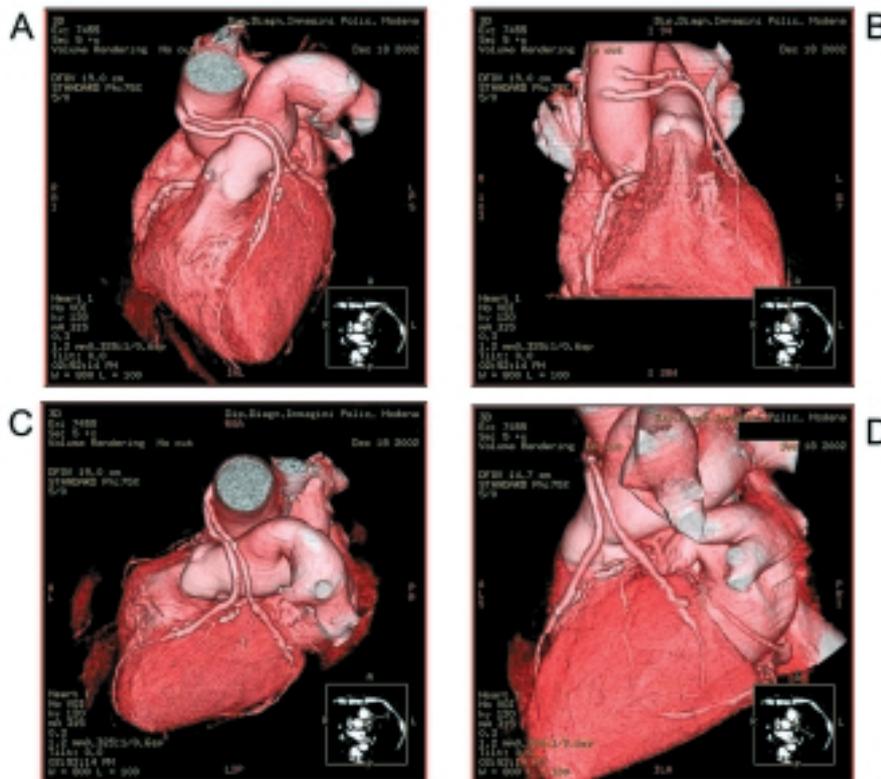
Volume rendering multislice computed tomographic images of a 65-year-old male, obtained 14 years following two-vessel coronary bypass. In the antero-posterior projection (A) the anatomic site of the two venous grafts may be visualized: the lowest directed to the left anterior descending artery, and the highest directed towards the obtuse margin of the heart. It is possible to note, moreover, the proximal anastomosis to the aorta (B) and the distal to the middle tract of the left anterior descending artery (B and C) and to the obtuse marginal artery (C and D). Three native coronary arteries are also visible: first and second diagonal branches (A and D) and the first tract of the right coronary artery (B).
